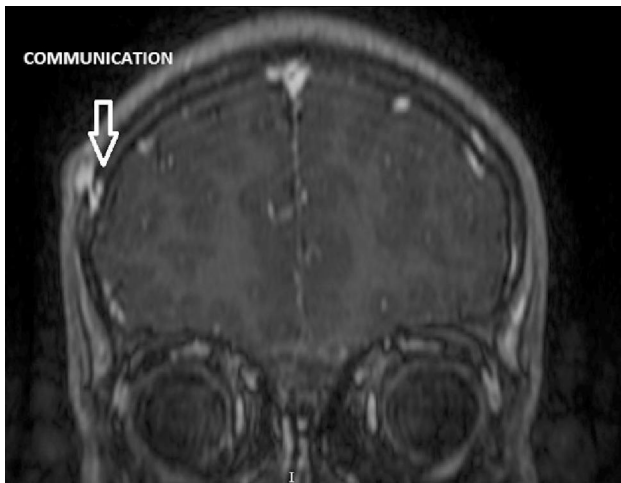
Coronal post-contrast T1-weighted MRI image showing dilated extracranial venous channels in right fronto-parietal region with a trans-calvarial communication with dural vein.
